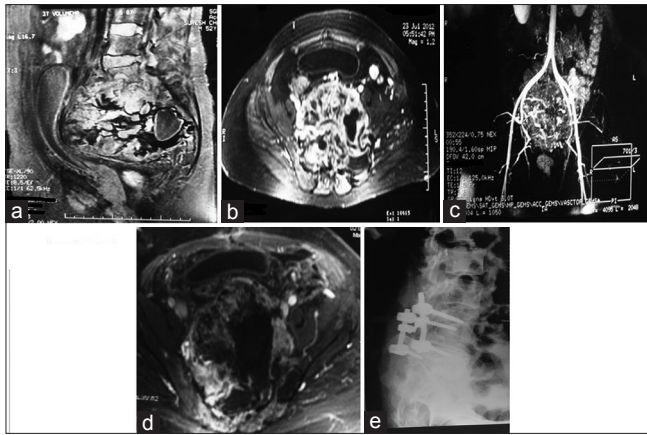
(a) Sagittal image showing heterogeneous contrast enhancing lesion involving the sacrum and extension into pelvis. (b) Coronal image showing heterogeneous contrast enhancing lesion involving the sacrum and extension into sacroiliac joint. (c) Magnetic resonance angiography showing extensive involvement of the bilateral iliac vessels. (d) Postoperative image showing subtotal resection of the lesion. (e) Postoperative lateral X-ray shows good cortical purchase of the sacral screws (L4-S1 pedicle screw fixation)
